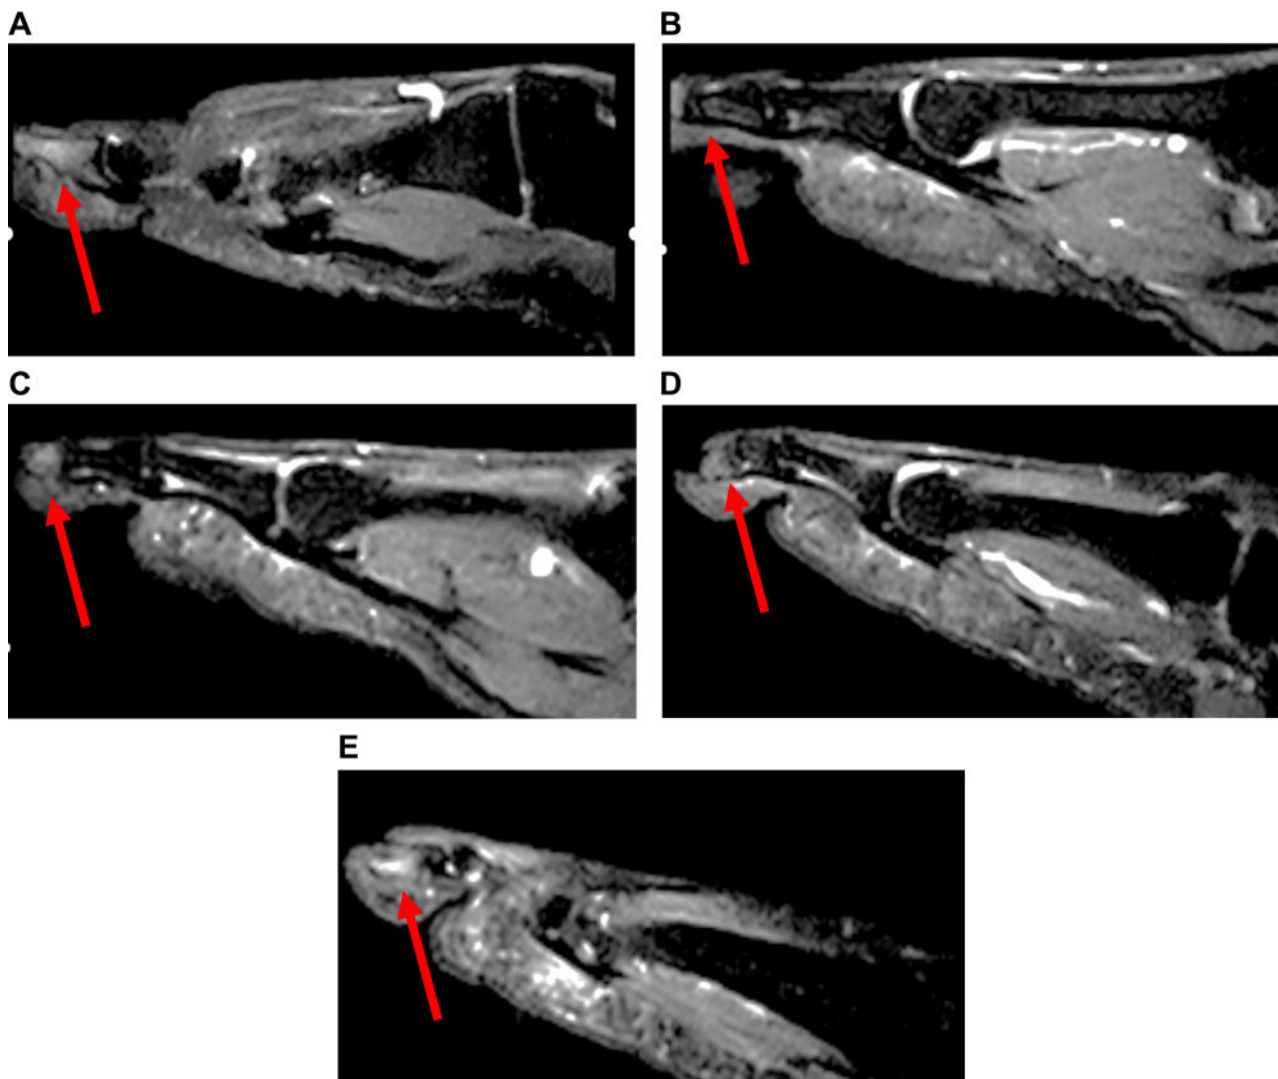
Magnetic resonance imaging showing distal to proximal migration of bone marrow edema in the (A) first, (B), second, (C) third, (D) fourth, and (E) fifth distal phalanges of the left foot.
